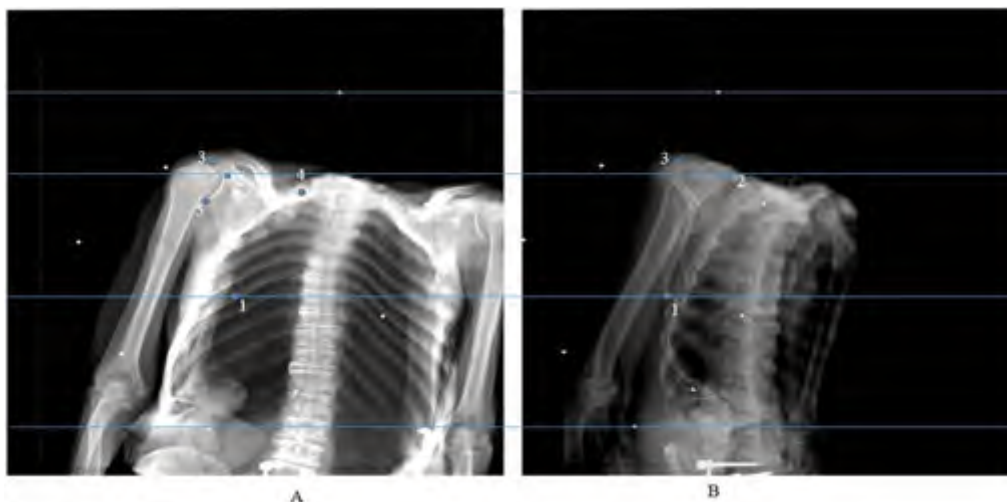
(A) AP and (B) Oblique lateral shoulder radiography. (1) Inferior angle, (2) Coracoid process, (3) Acromion (4) Superior angle and (5) Infra glenoid rim
